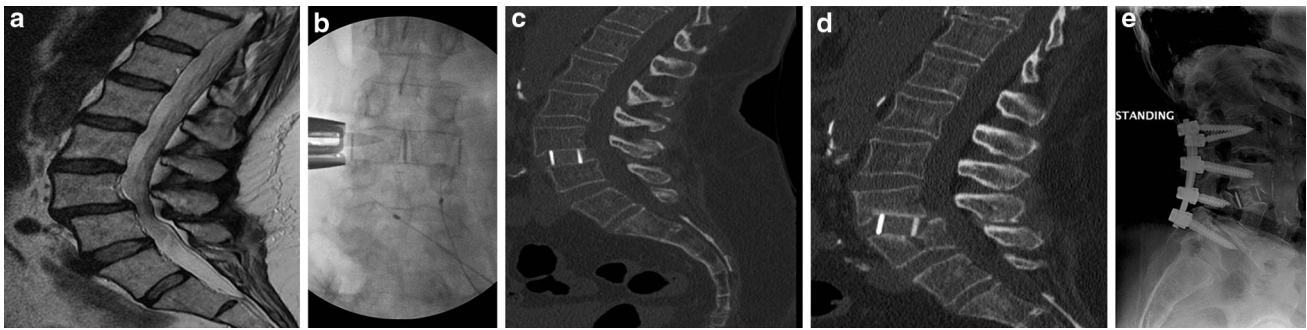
Preoperative MRI (a) reveals grade I spondylolisthesis with moderate canal stenosis. Intraoperative fluoroscopy (b) demonstrates graft placement with significant disc space distraction and no endplate violation. Postoperative CT imaging (c) reveals good positioning of stand-alone interbody graft within the L3/4 disc space without evidence of endplate violation or graft subsidence; however, the disc
